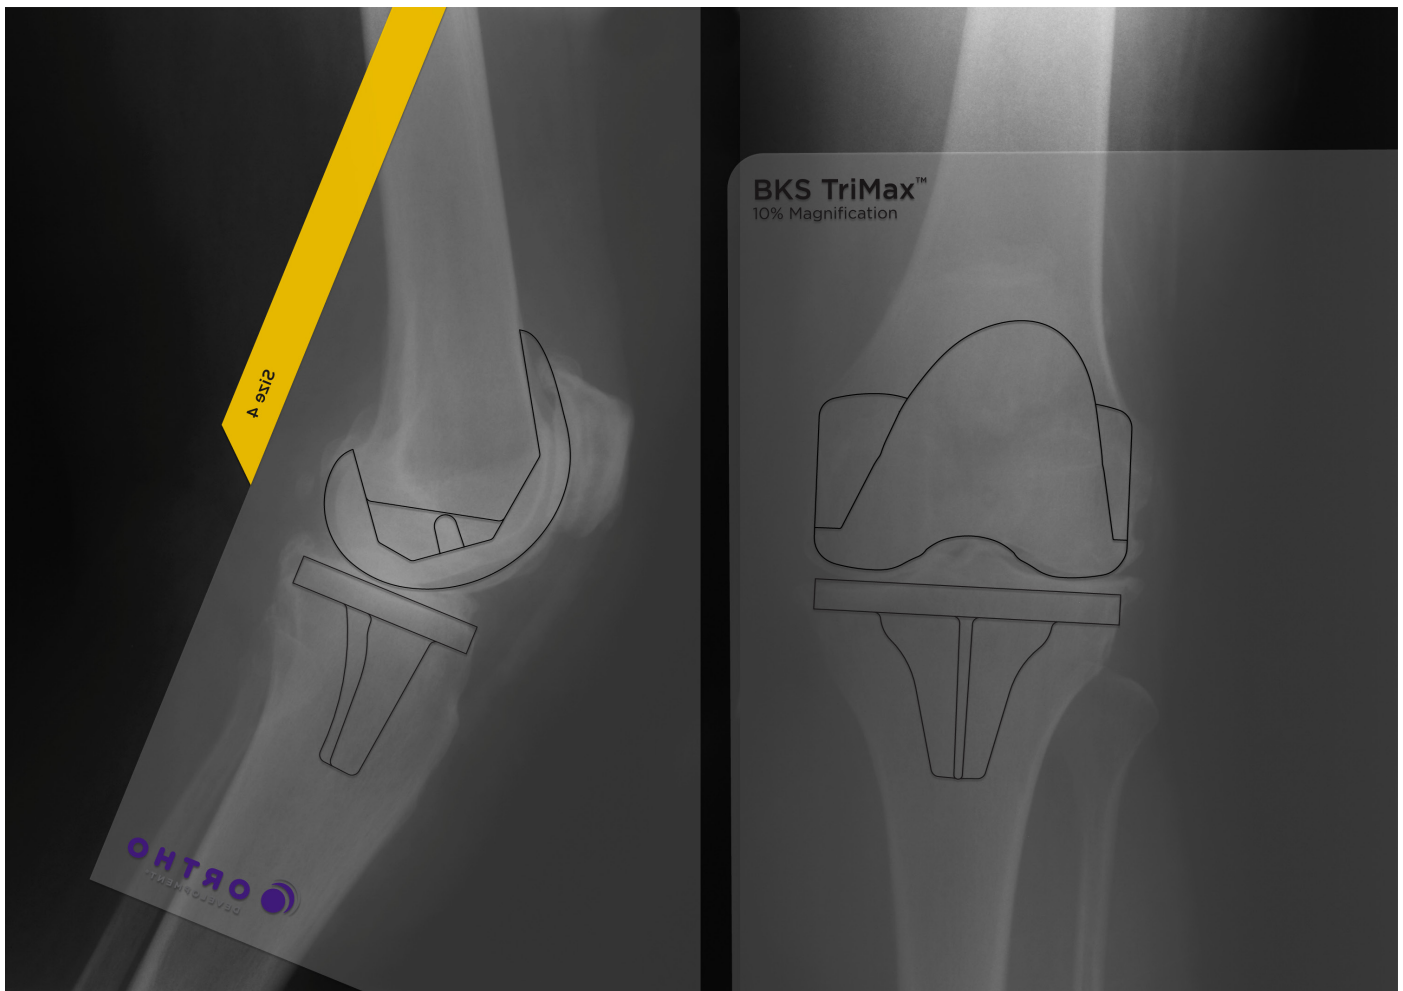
Template overlaid on radiograph
